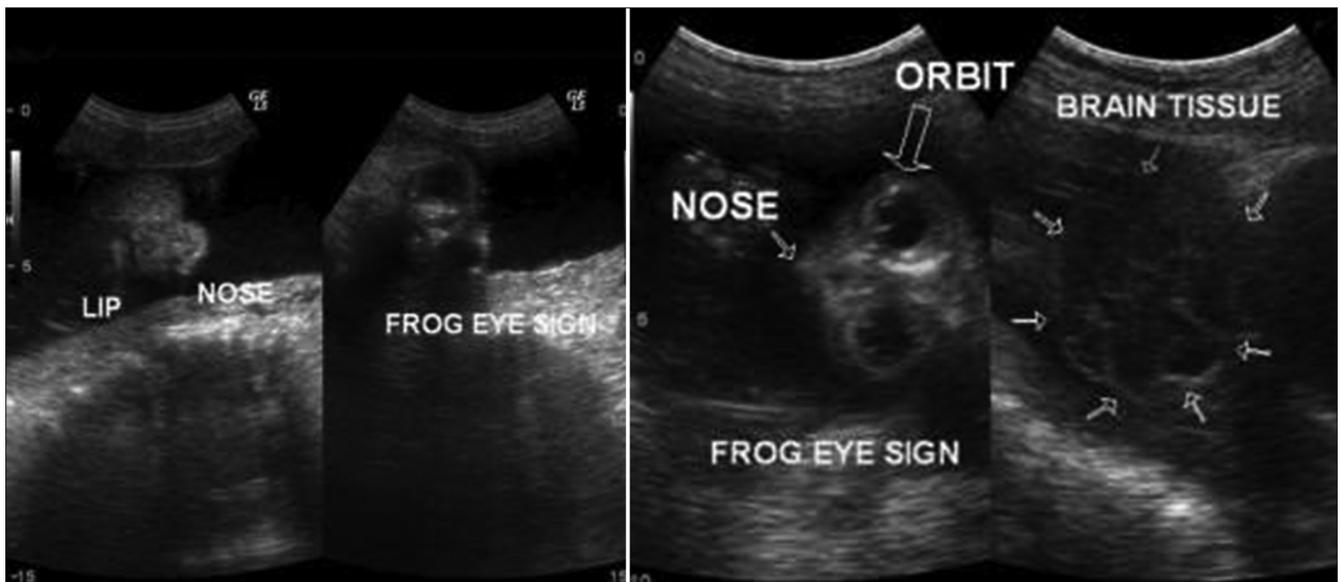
(a and b) Ultrasound images showing the absent calvaria and exposed brain tissue
